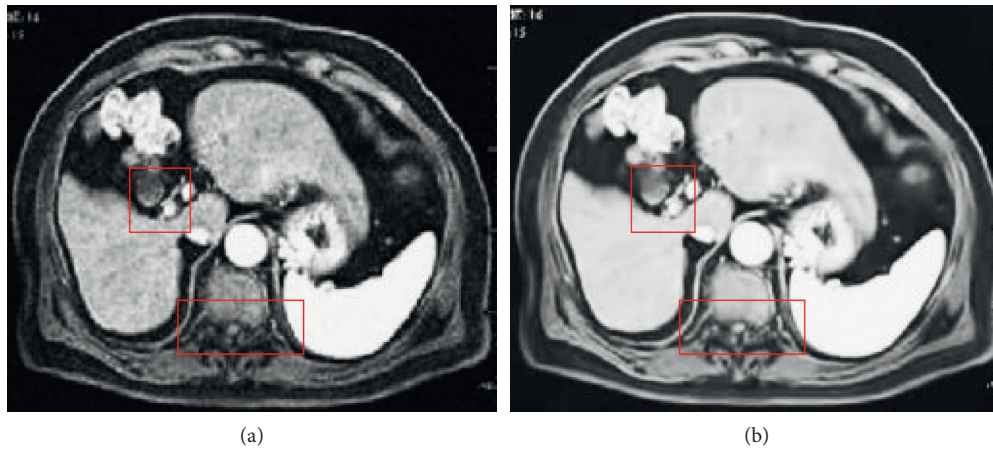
Comparison of original MRI image and denoising result image. (a) MRI image. (b) MRI image after low rank matrix denoising.
